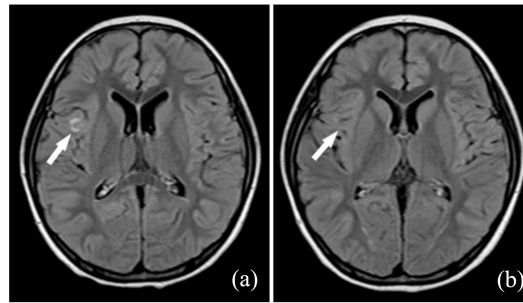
Case 2 MRI. A 1.4-year-old girl with fever and headache for three weeks. (a) Contrast-enhanced MRI T2WI-FLAIR sequence showed a linear abnormal signal focus on the surface of the cerebral gyrus; (b) After the treatment, the lesions disappeared
